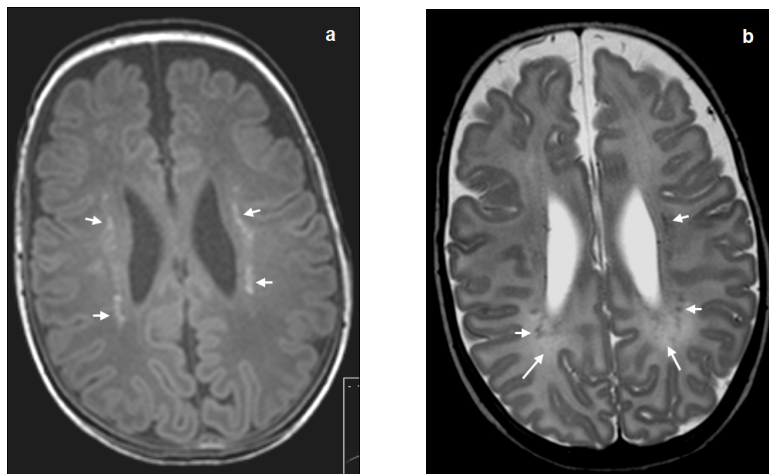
Transverse T_1 - (a) and T_2 - (b) weighted MR images at high ventricular level of a preterm infant (gestational age 26.9 weeks) at a postmenstrual age of 42.7 weeks showing bilateral, multiple punctate white matter lesions in the periventricular white matter (short arrows), being more obvious on the T_1 - than on the T_2 -weighted MR image. Also showing widening of the extracerebral spaces and dilated, irregularly shaped lateral ventricles. The T_2 -weighted image additionally shows diffuse and excessive high signal intensity (DEHSI) in the periventricular white matter around the occipital horns of the lateral ventricles (long arrows).
